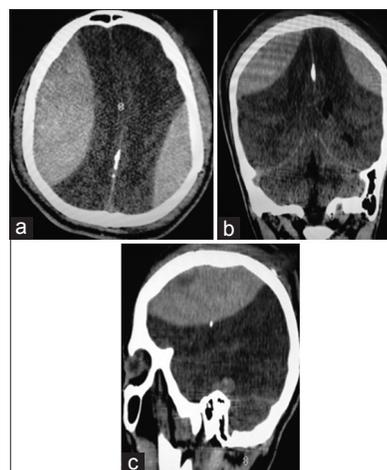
Initial brain computer tomography (CT) of the patient. (a) Axial, (b) Coronal and (c) Sagittal slices demonstrating two hyperdense areas, latter confirmed as bilateral hematomas, the right one (144.5 cm^3) and the left one (61.3 cm^3)
